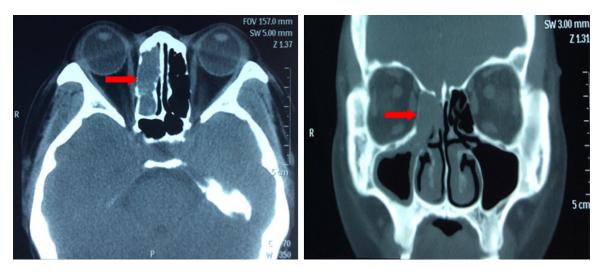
The head computed tomography (CT) scan showed a destructive soft-tissue mass (arrow) in the right ethmoid sinus and frontal sinus.
